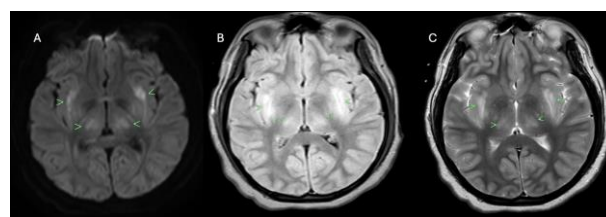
Uremic encephalopathy with characteristic lentiform fork sign. (A) Axial DWI, (B) Axial FLAIR, and (C) Axial T2-weighted images demonstrate bilateral symmetric signal abnormalities involving the lentiform nuclei and thalami. The hyperintense signal outlining the putamina creates the distinctive "lentiform fork sign," a characteristic finding in uremic encephalopathy typically associated with metabolic acidosis in renal failure.
